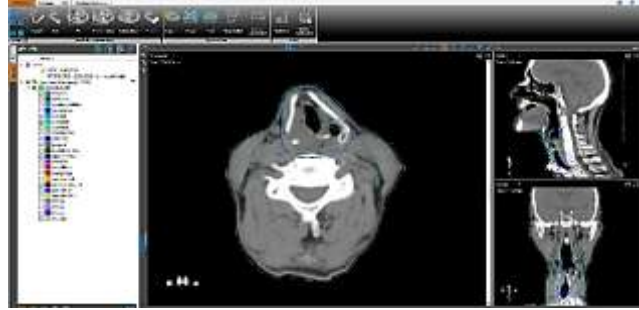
A patient being treated for squamous cell carcinoma of the larynx during her dosimetric CT scan.
